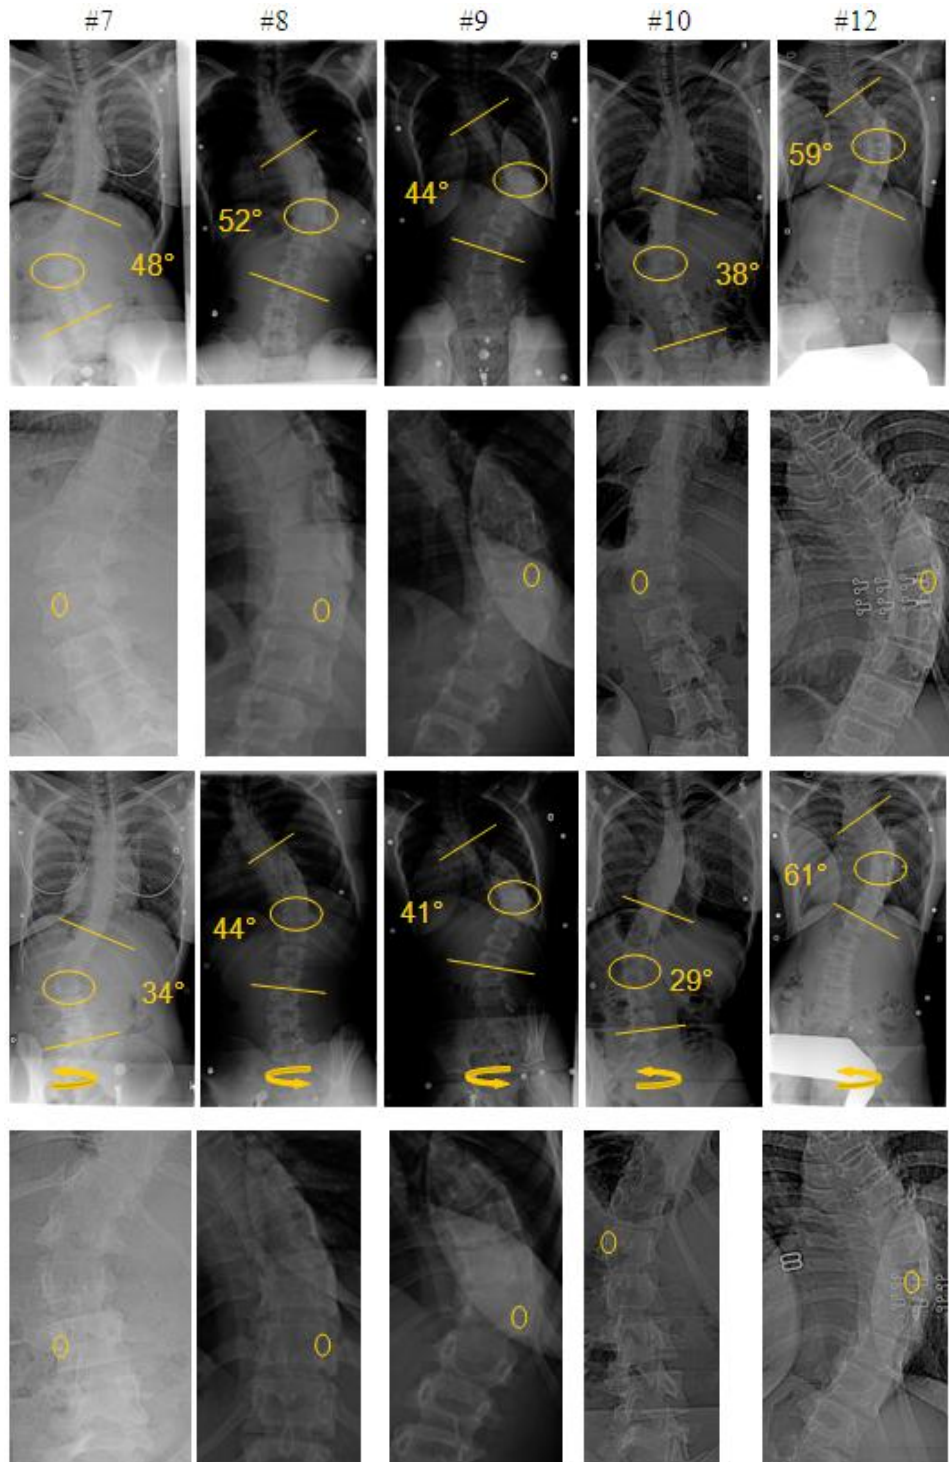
(A4T3): Radiographs of patients 7 to 10 and 12 in the neutral prone (1st and second row) and twisted pelvis positions (3rd and fourth row); arrow indicates direction of pelvic torsion
